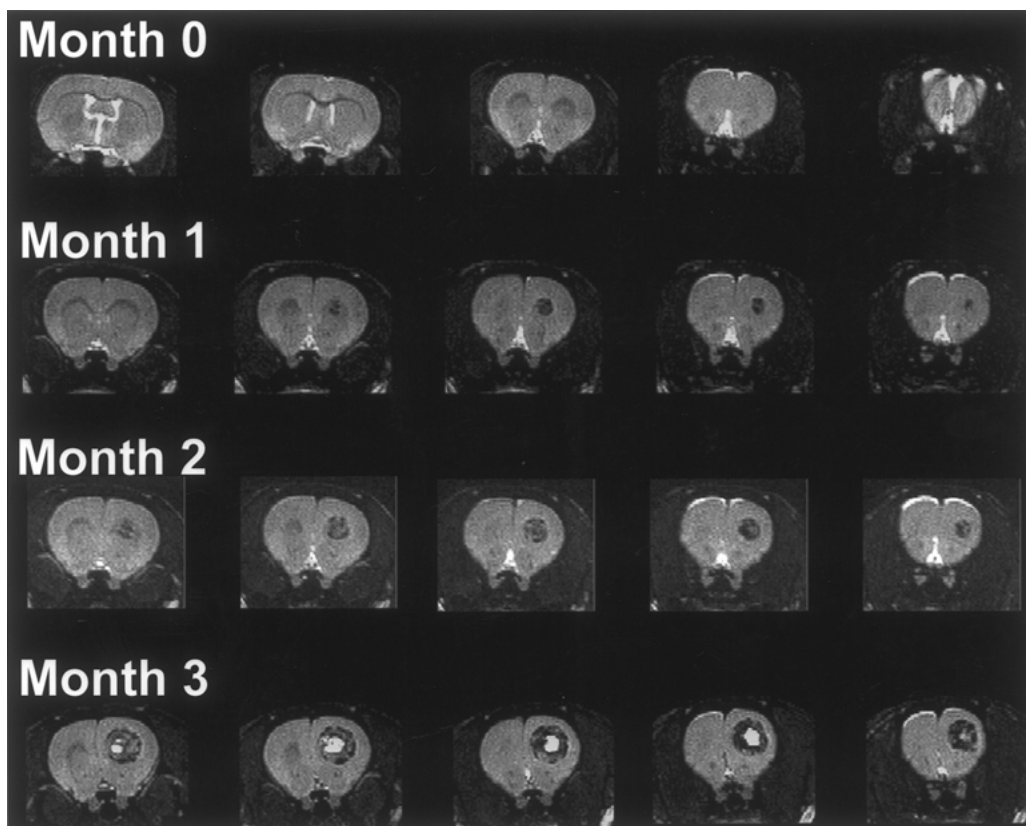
Growth of ENU-induced brain tumors. MRI images of a representative tumor over several months. Tumor masses exhibited slow growth, characterized by slow expansion of the low signal intensity core. In addition, a number of tumors developed cysts after several months of growth.
